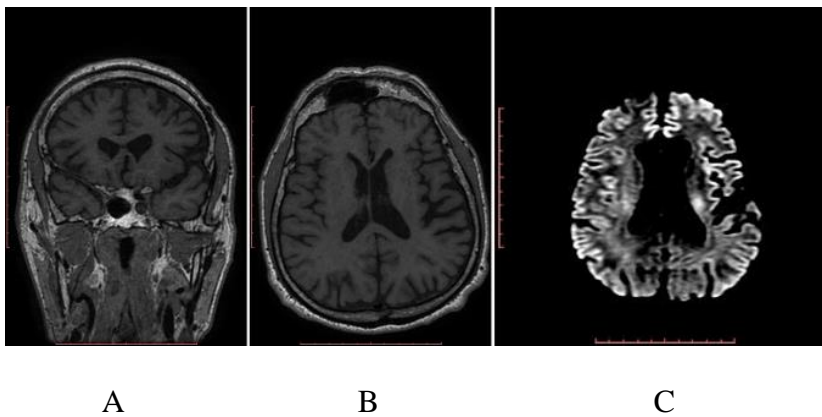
Coronal T1-weighted (A), axial T1-weighted (B) and axial diffusion-weighted (C) brain imaging at initial assessment showing left perisylvian atrophy.
